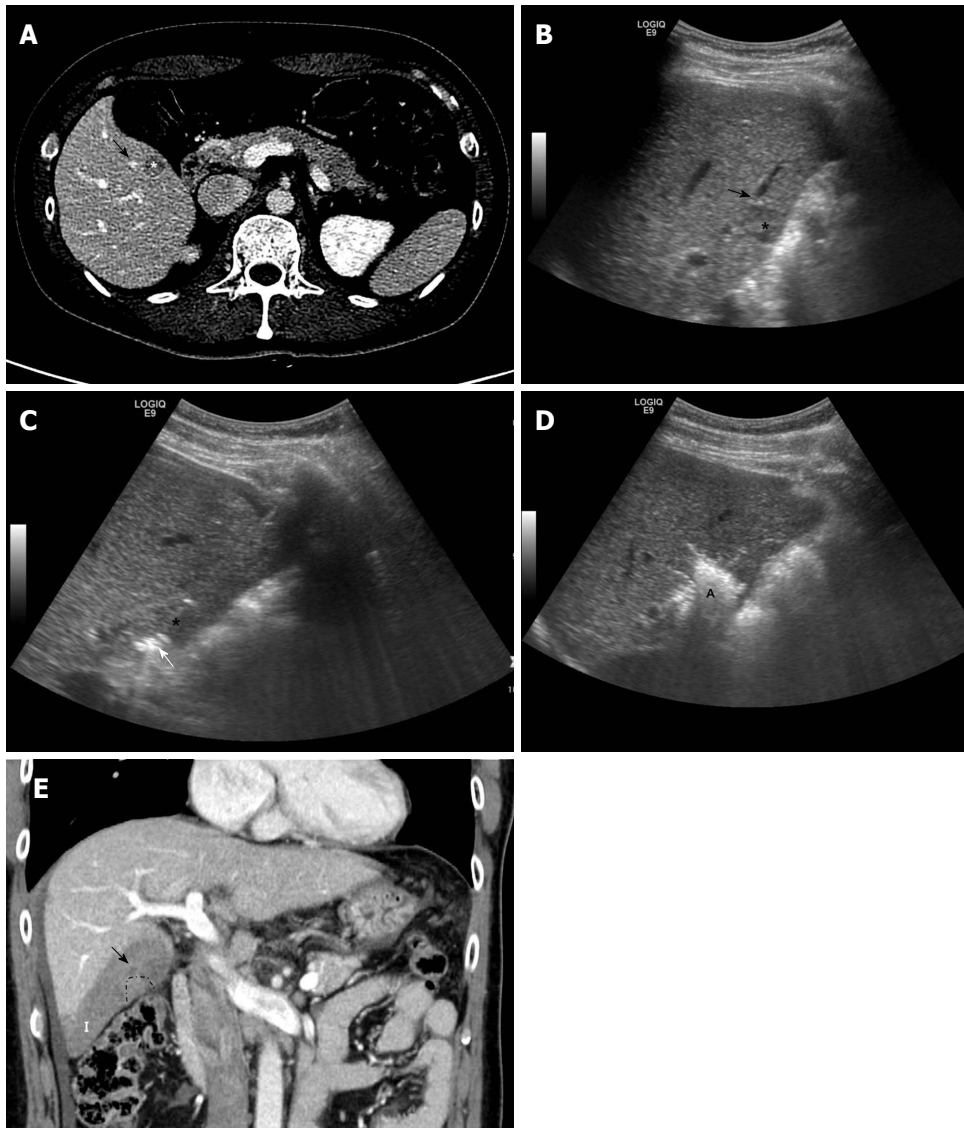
Images showing subsegmental hepatic infarction after radiofrequency ablation for perivascular hepatocellular carcinoma. A: Axial computed tomography image obtained during equilibrium phase shows 1.3-cm hepatocellular carcinoma (asterisk) in segment V before radiofrequency (RF) ablation. The index tumor is in contact with the right portal vein (black arrow); B: Planning ultrasound image obtained before RF ablation shows the low-echoic-index tumor (asterisk) in contact with a right portal vein (black arrow); C: During RF ablation, the RF electrode (white arrow) is inserted into the index tumor (asterisk), evading the adjacent portal vein; D: At the end of the procedure, a hyperechoic ablation zone (A) completely covered the index tumor; E: Thrombosis within the peritumoral portal vein (black arrow) developed around the index tumor (dotted line), shown on coronal computed tomography images obtained immediately after RF ablation. This led to subsegmental infarction (I) in the peripheral area of hepatic segment VI.
